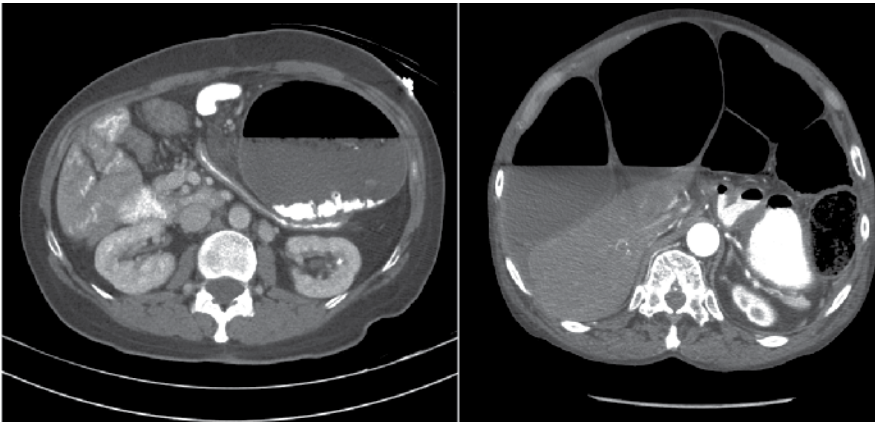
Colonic pseudo-obstruction following cardiac surgery. The first patient (left) presented with increasing abdominal pain/distention, nausea and vomiting following mitral valve replacement. Abdominal CT showed massively dilated left colon with compressive effect on the surrounding small bowel. The pseudo-obstruction resolved with neostigmine therapy. The second patient (right) developed diffuse colonic dilatation following coronary artery bypass grafting. His pseudo-obstruction resolved promptly following emergent colonoscopic decompression.
